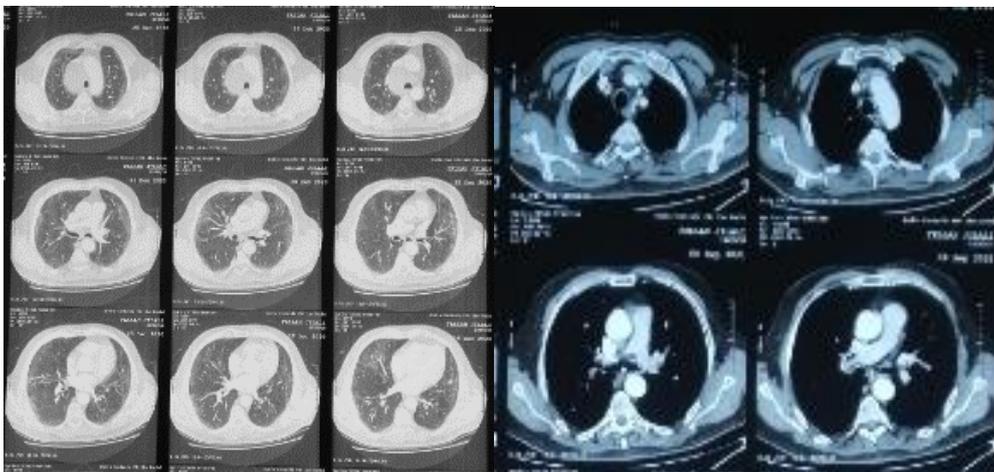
Control CT scan of the chest
